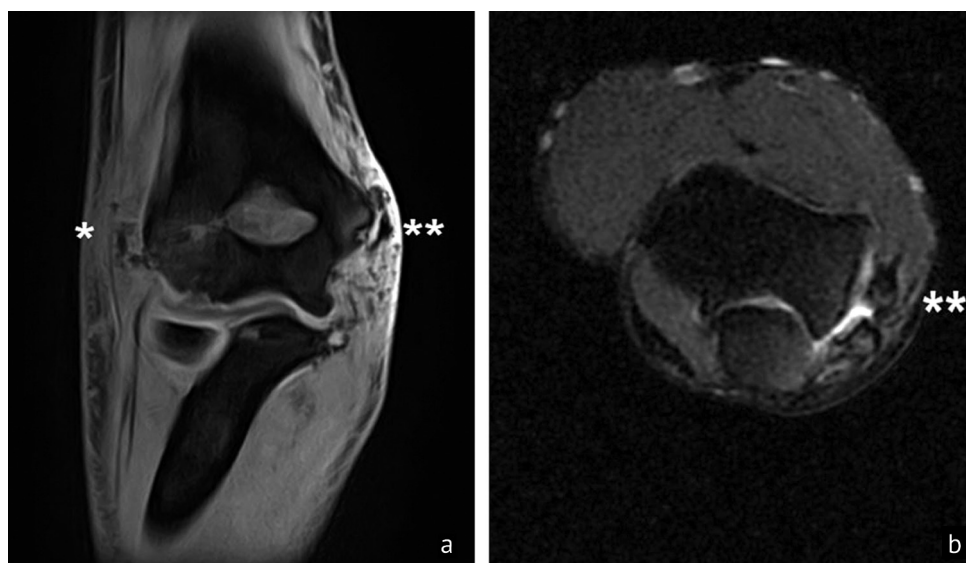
MRI of post-traumatic instability of the elbow joint of the left upper limb in sagittal (a) and coronal (b) sections of the T1-weighted MRI mode, with visualization of the viability of the MULC autotenograft (*) and LCLC ligamentization () 6 weeks after surgical treatment
